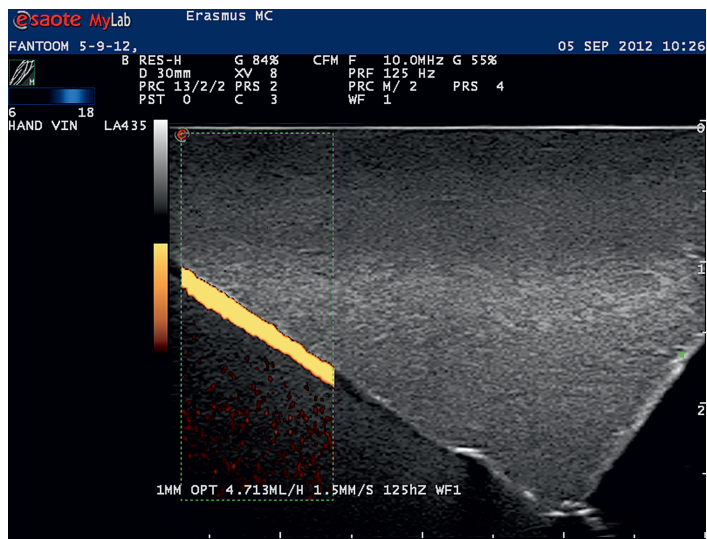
A continuous power Doppler ultrasound signal in a 1 mm vessel on Machine B.
